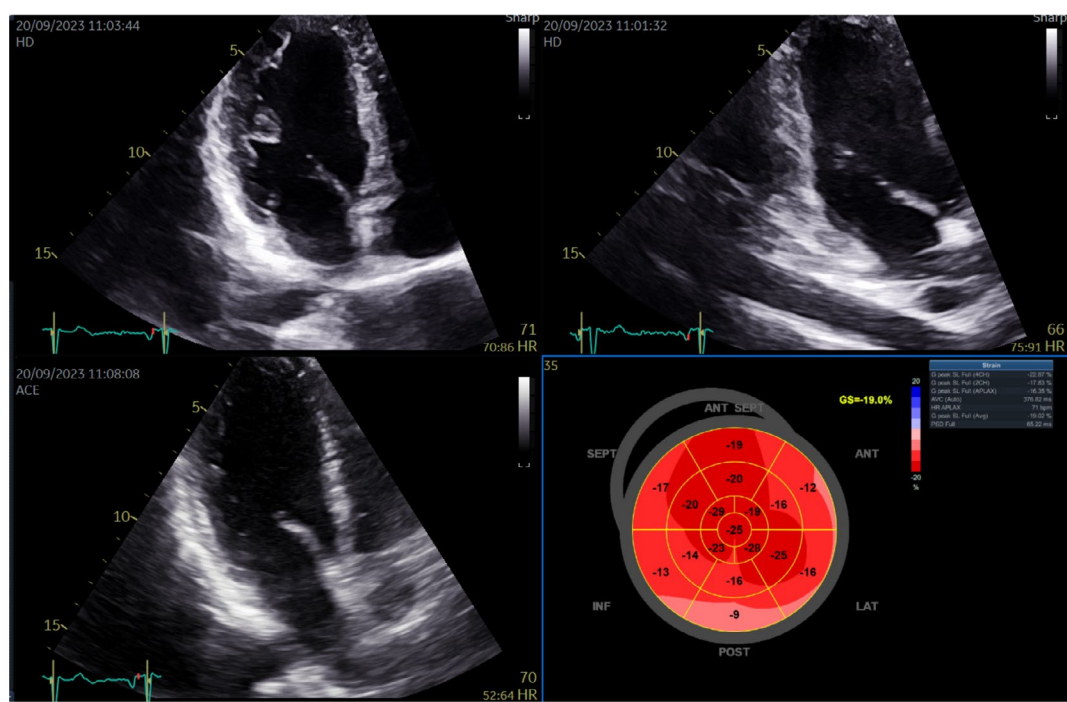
Two-dimensional speckle tracking echocardiography
